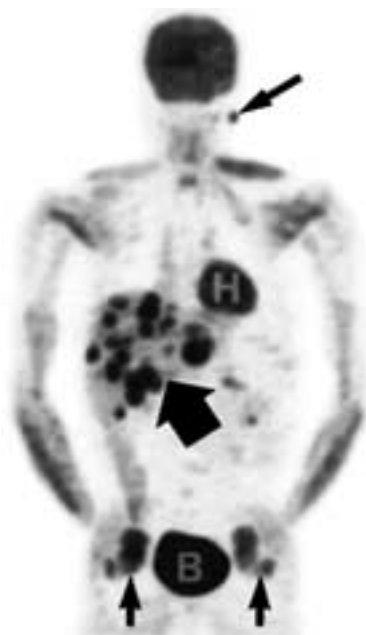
A 36-year-old HIV-positive man with a history of Merkel cell carcinoma of the parotid region, was referred with locally recurrent disease for consideration of definitive therapy. A staging chest x-ray and liver function tests were normal. A whole-body FDG PET scan demonstrates focal activity in the left parotid region (*long, thin arrow*), as well as multiple foci of intense tracer accumulation in the liver (*thick arrow*). Abdominal CT scan and fine needle aspiration confirmed metastatic Merkel cell carcinoma, and the patient was treated with palliative chemotherapy. The whole-body scan shows normal activity in the heart (*H*) and bladder (*B*), as well as activity in the hands bilaterally (*short, thin arrows*) and forearm muscles related to finger clenching.
